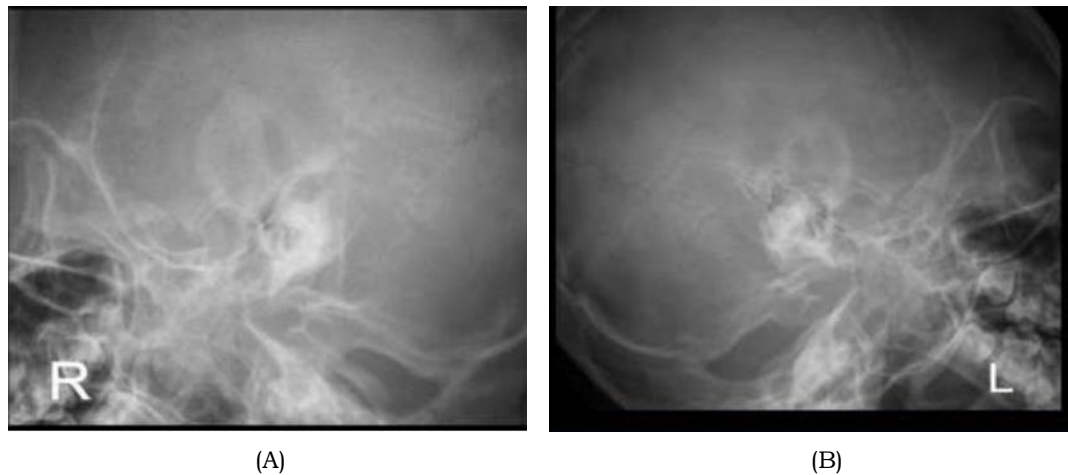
Schuller views radiography. (A) right ear; (B) left ear.
